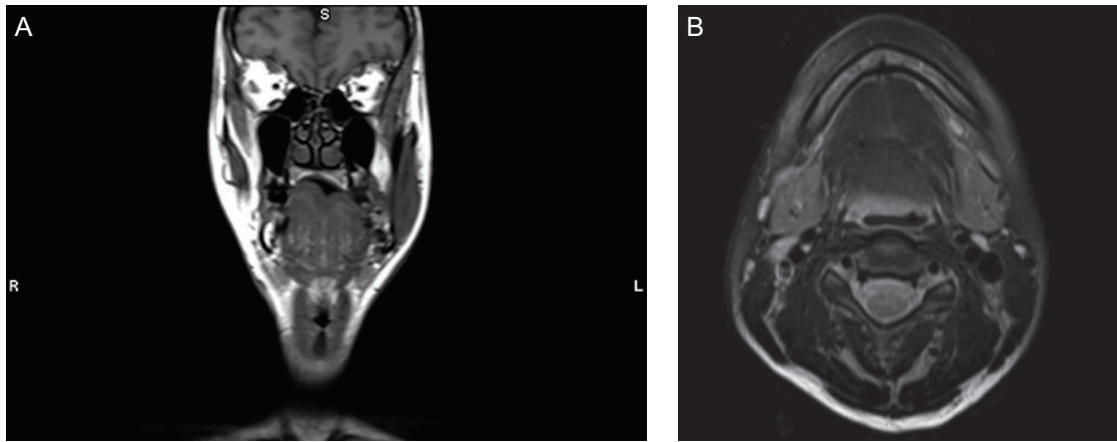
Static MRI revealed hypoplasia of the right masseter muscle without apparent hypoplasia of the mandible. Sagittal (A) and axial (B) views are shown.
